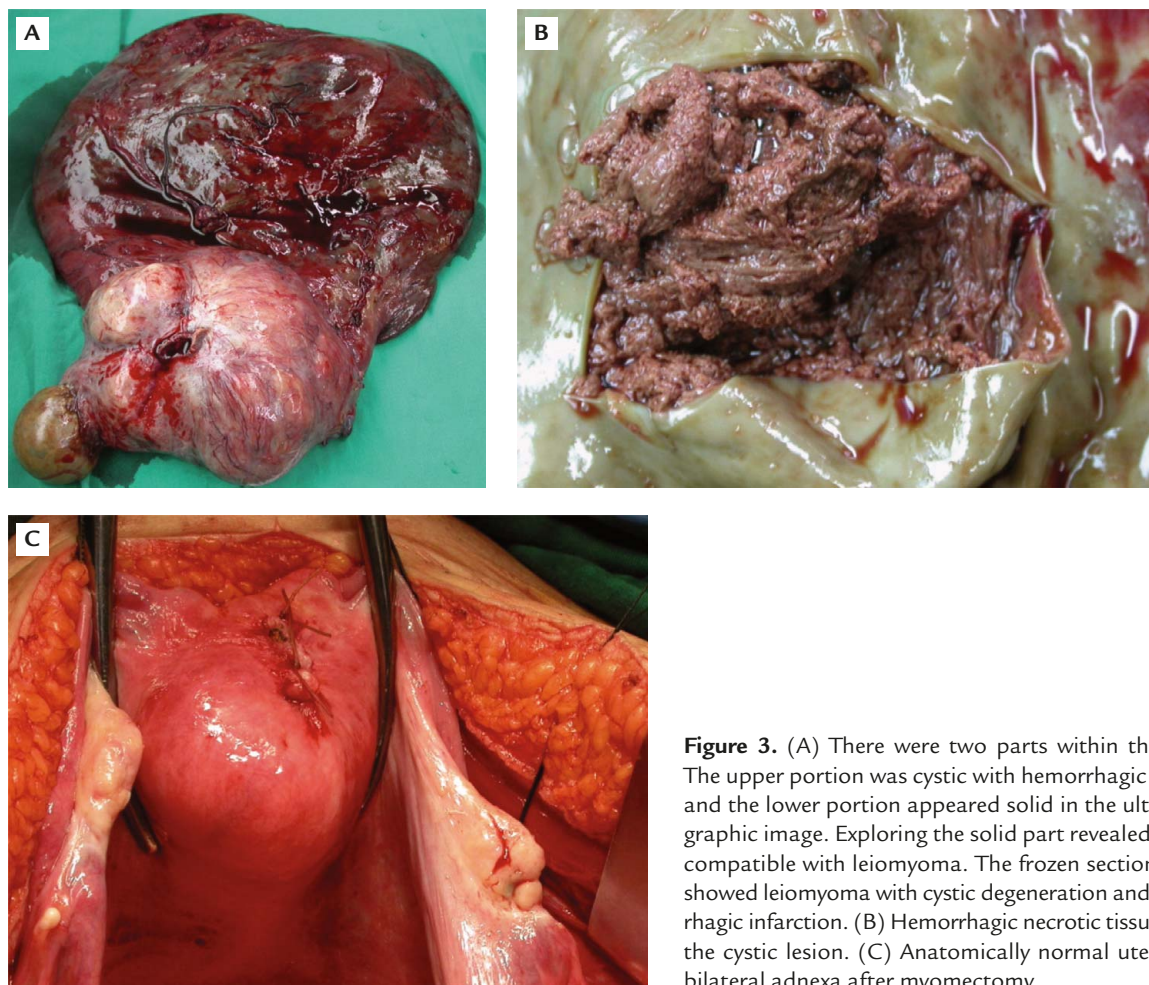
(A) There were two parts within the mass. The upper portion was cystic with hemorrhagic lesions, and the lower portion appeared solid in the ultrasonographic image. Exploring the solid part revealed it to be compatible with leiomyoma. The frozen section report showed leiomyoma with cystic degeneration and hemorrhagic infarction. (B) Hemorrhagic necrotic tissue within the cystic lesion. (C) Anatomically normal uterus and bilateral adnexa after myomectomy.
